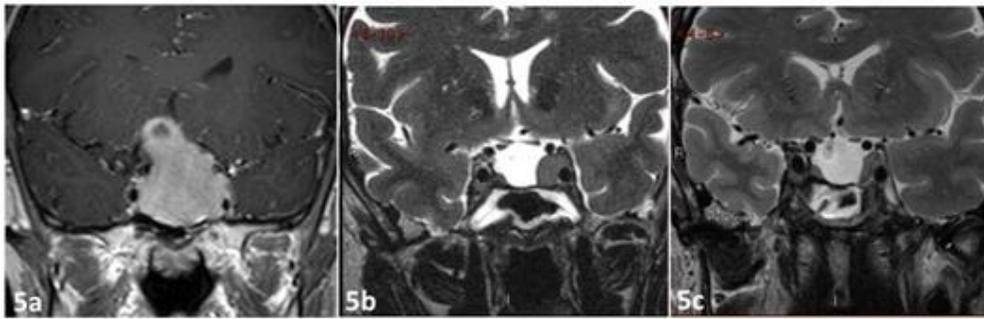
Example of a large pituitary adenoma treated with combined approach. This 13 year-old female patient presented with marked reduction of visual acuity especially on the right side and with a homonymous hemianopia. Endocrine evaluation revealed a non-functional tumor with partial anterior pituitary dysfunction. MRI with gadolinium enhancement showed a large pituitary adenoma, Hardy's grade D, Knosp IV, with bilateral invasion of the cavernous sinus (5a). She underwent a staged trans-nasal trans-sphenoidal endoscopic resection of the tumor. The vision on the left side partly improved while the visual field deficit of the right eye completely recovered. She needed hormonal substitution for the hypopituitarism. A residual tumor located bilaterally in the cavernous sinus was visible on T2-weighted coronal MRI (5b). The tumor volume before surgery was 20.3 cc while the target volume at the time of radiosurgery was 1.1 cc. GKS was performed with a dose of 12 Gy at the 50% isodose for both right and left targets, while the maximal dose to the optic pathway was 8.5 Gy. Six months following GKS, there is a marked reduction of the residual tumor (5c).
